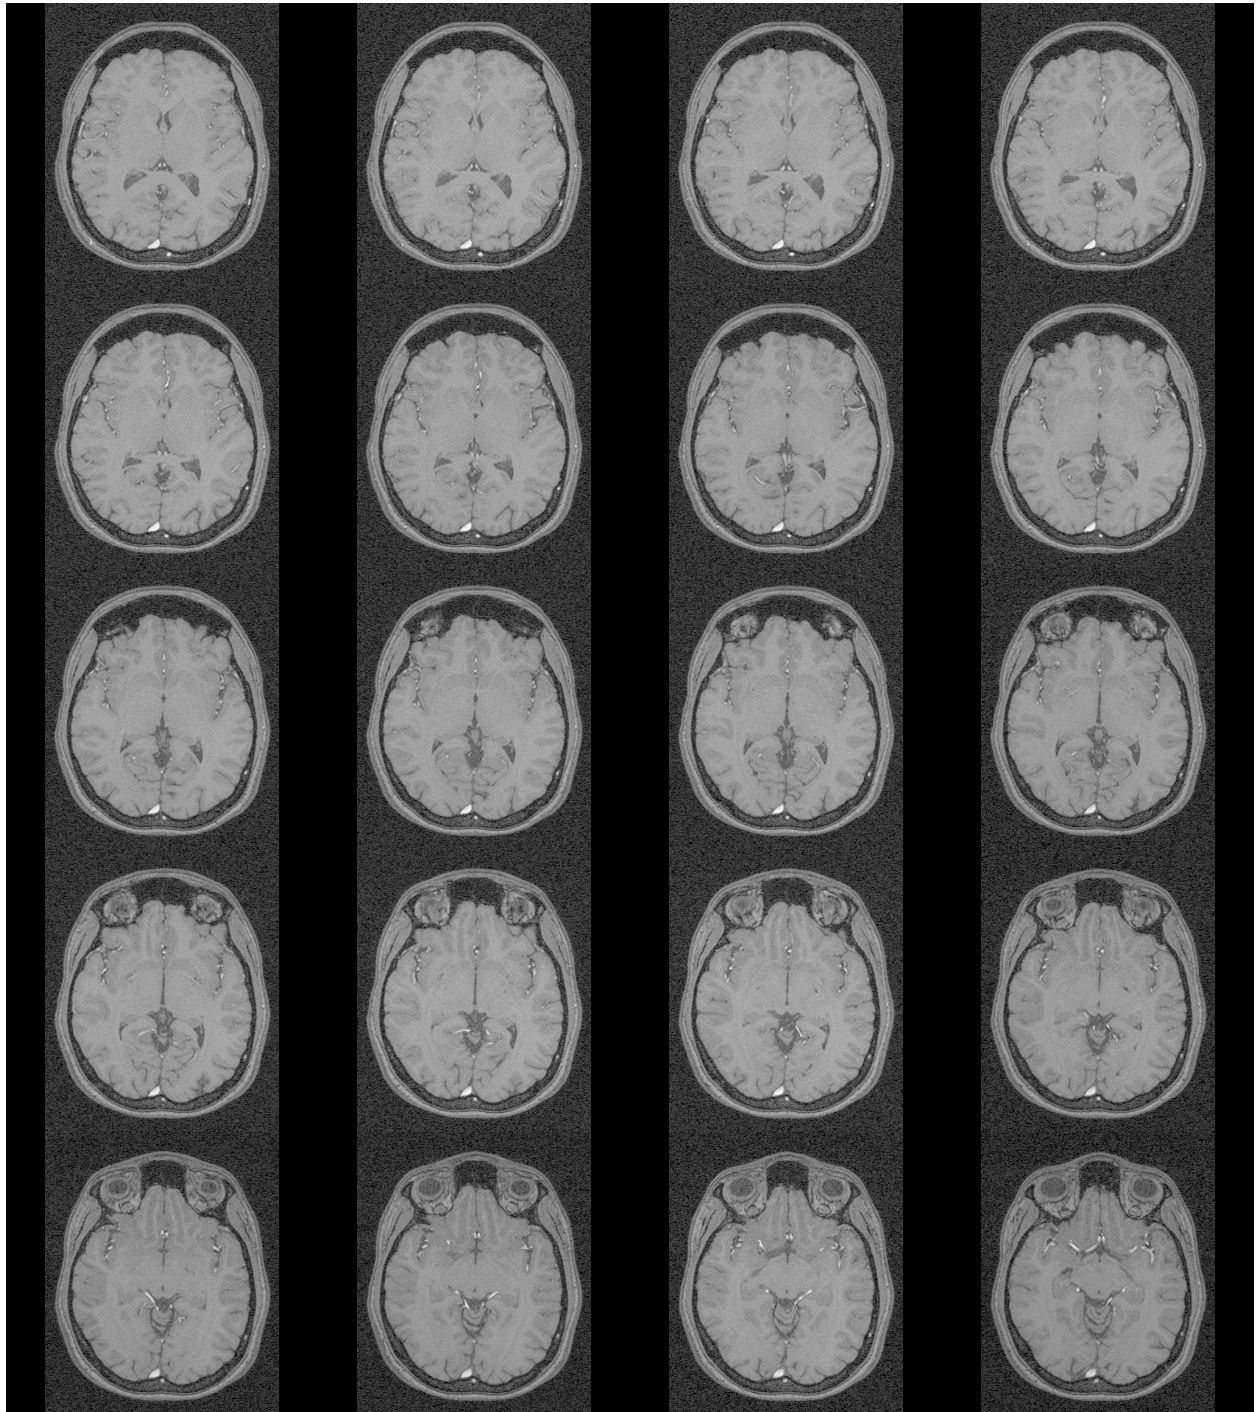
A sequence of MR image slices
